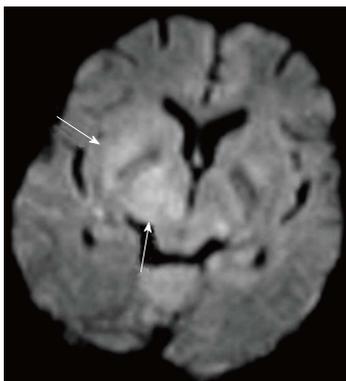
Diffusion weighted image from the Brain magnetic resonance imaging of an human immunodeficiency virus-positive patient with lymphoma shows restriction in the right lentiform nucleus and the thalamus (arrow).
